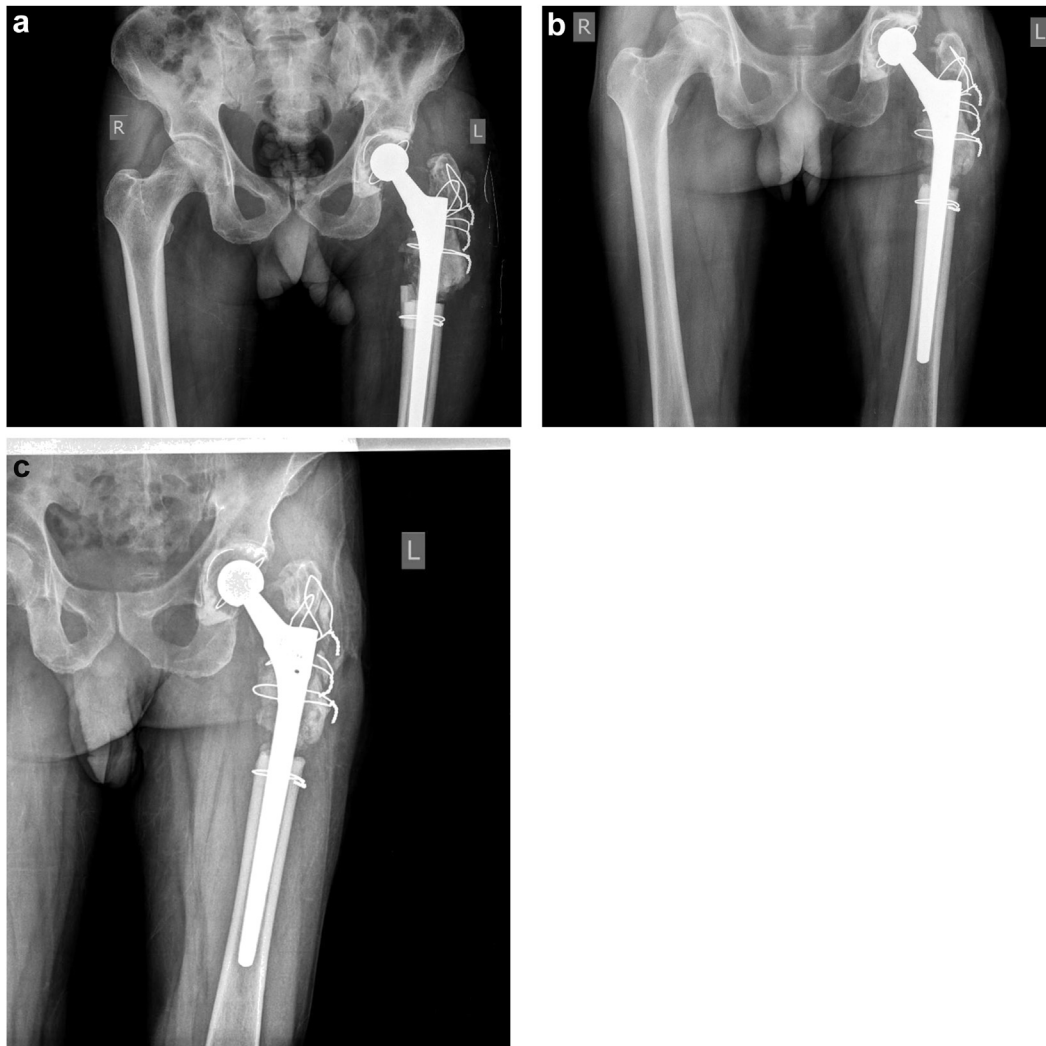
Follow-up pelvis radiographs showing good osteointegration and gradual bony union. (a) Postoperative anteroposterior radiograph at the end of 6 weeks. (b) Postoperative anteroposterior radiograph after 1 year. (c) Postoperative anteroposterior radiograph after 2 years.
